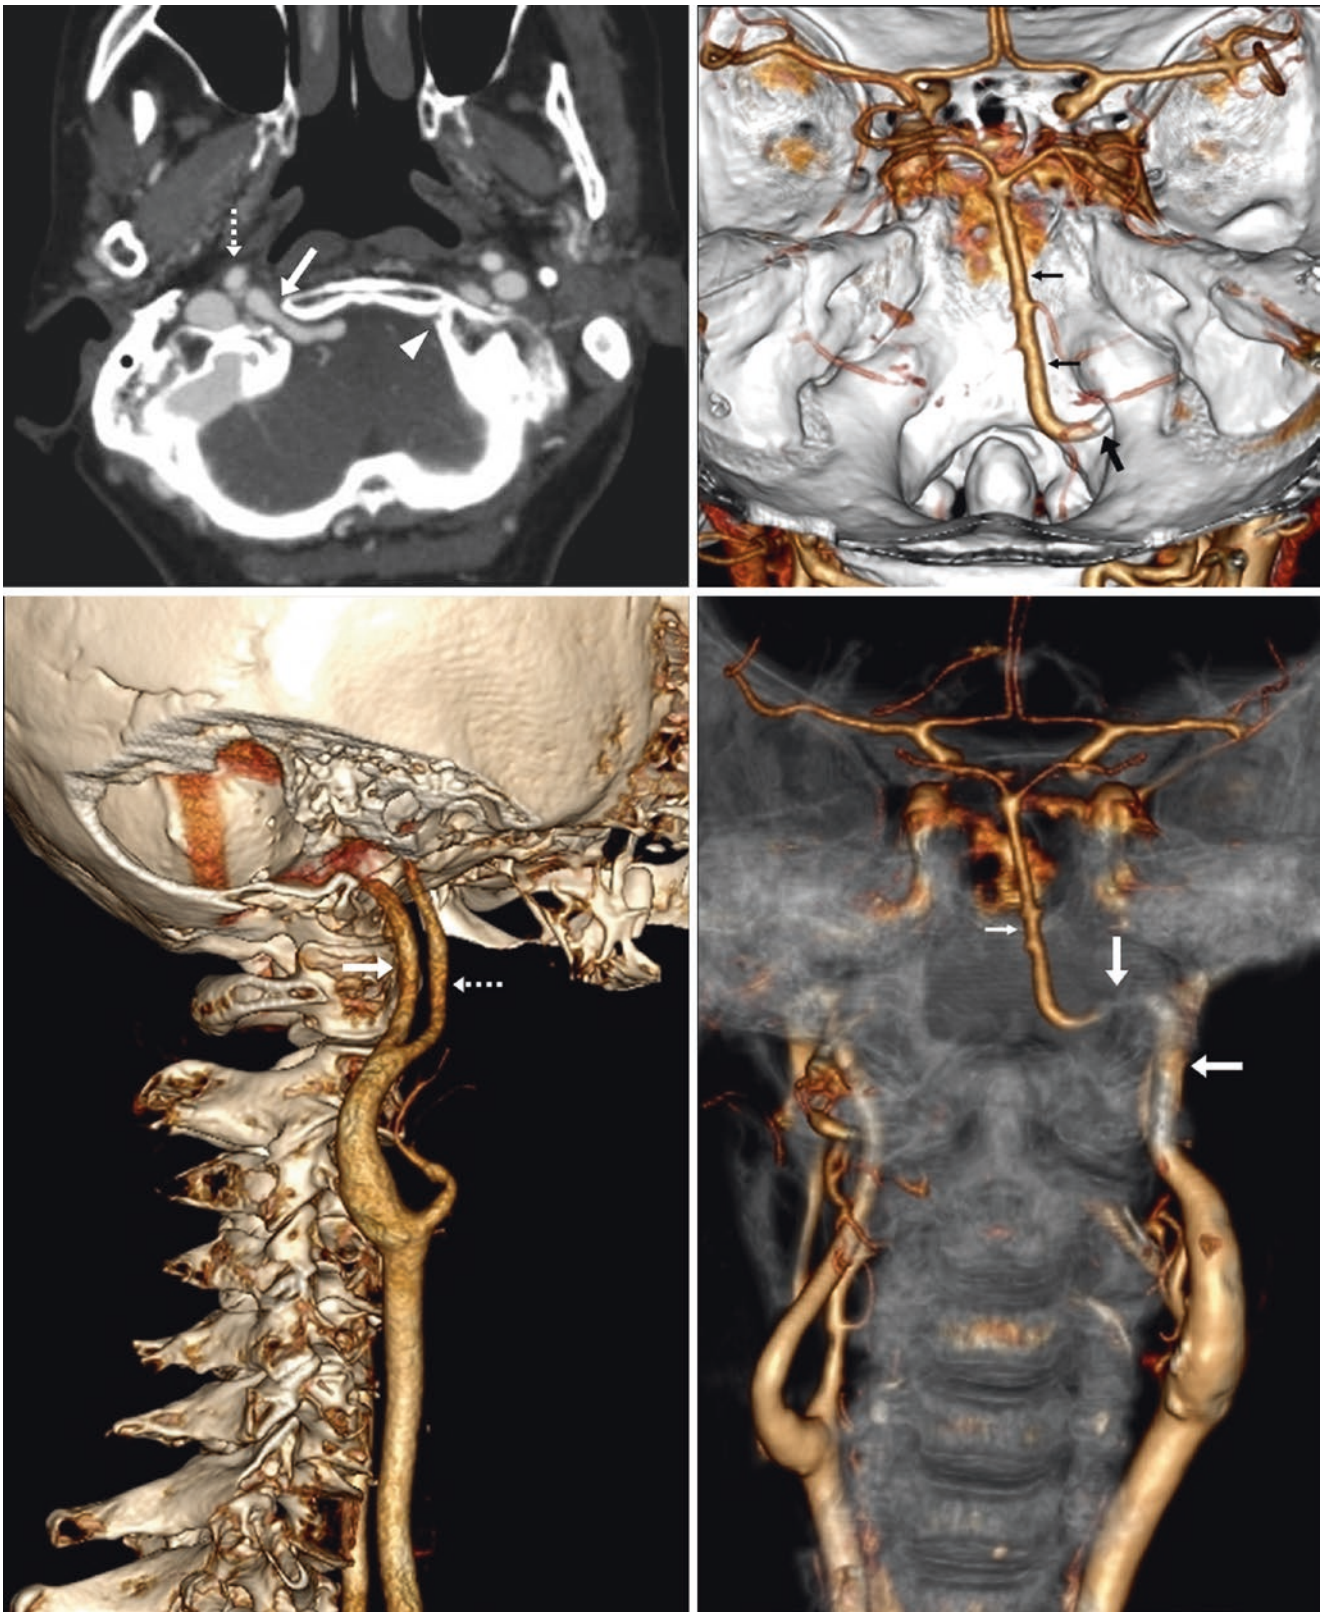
79-year-old with throat pain. The patient had a right PHA (large arrows), which was depicted on a CTA's axial source images (top left), as well as on a 3D VR PA view (top right), a right lateral view (bottom left), and on a "transparent bone" 3D PA view (bottom right).
